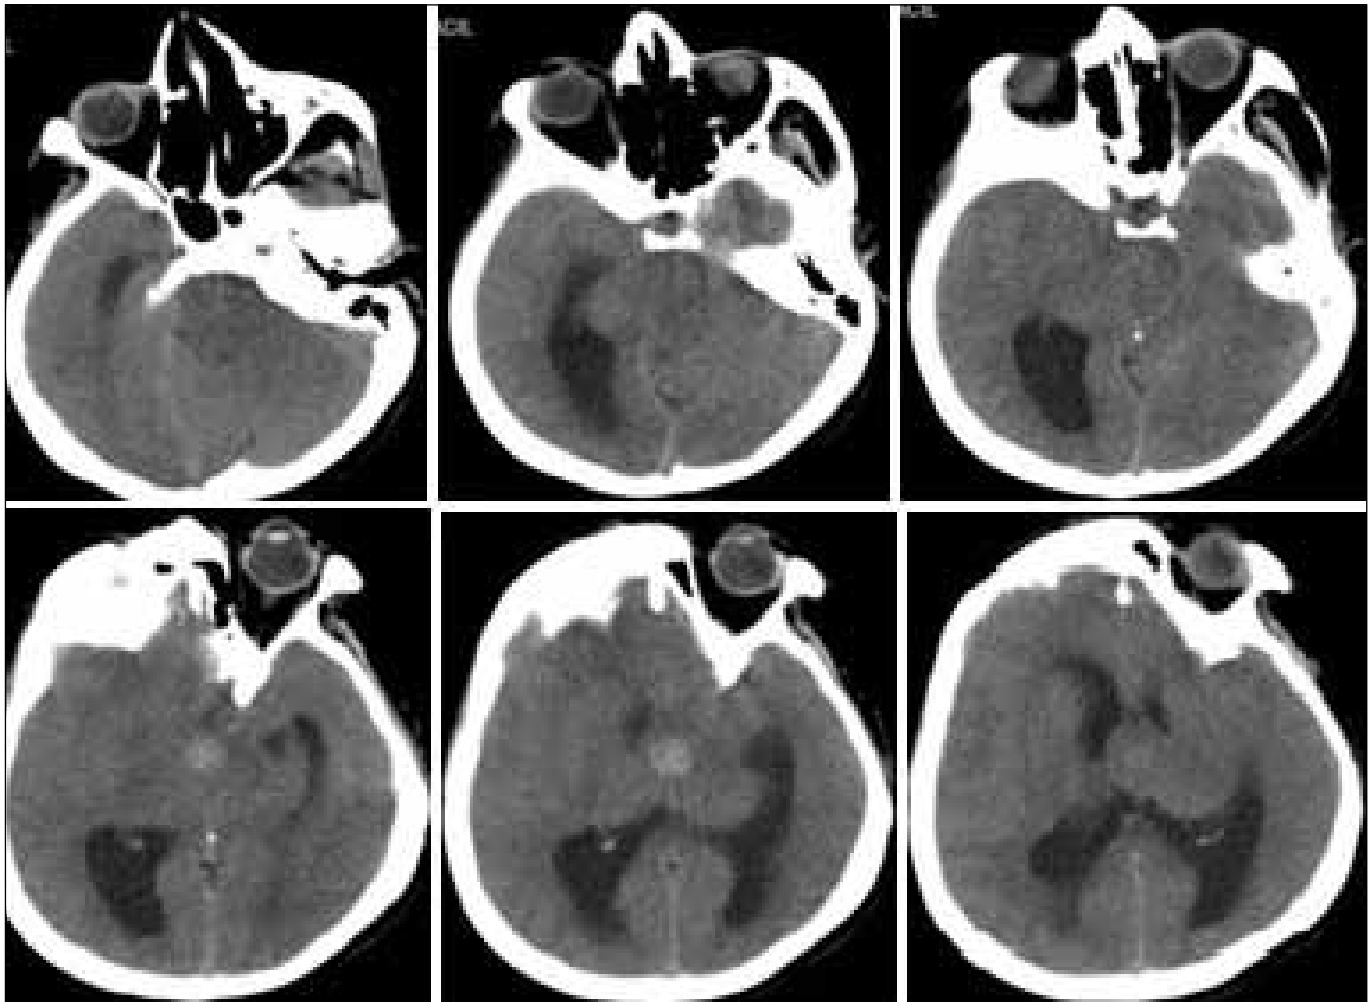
Admission CT of patient 11. A CC with 23 mm diameter (isodense) and 14 mm hyperdense center. The perimesencephalic cisterns could not be identified clearly.
